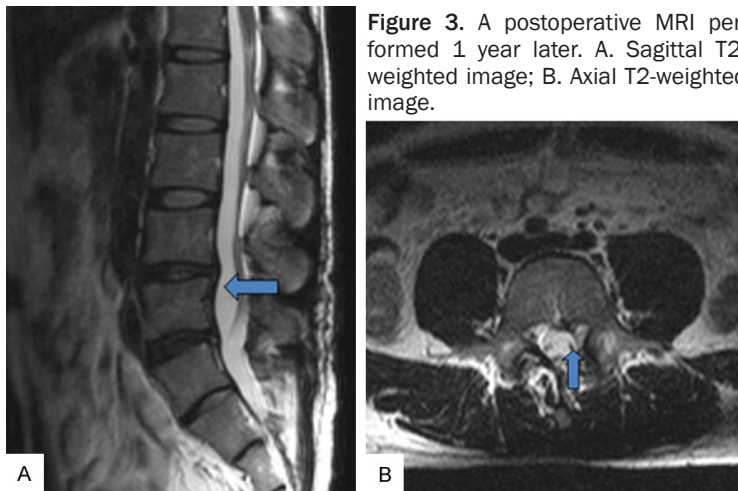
A postoperative MRI performed 1 year later. A. Sagittal T2-weighted image; B. Axial T2-weighted image.
